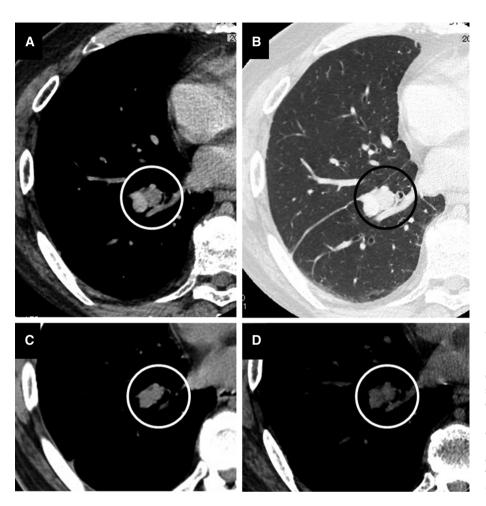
The chest CT scans of the present case. (A) Chest CT at the initial examination shows a polypoid lesion with poor contrast enhancement in the right lower lobe branch. (B) The background of the lung shows no significant change. (C) Chest CT performed 3 years and 10 months previously. The endobronchial lesion showed minimal enlargement over 3 years and 10 months. (D) The chest CT scan after 6 months. The size of the lesion is stable for 6 months.
